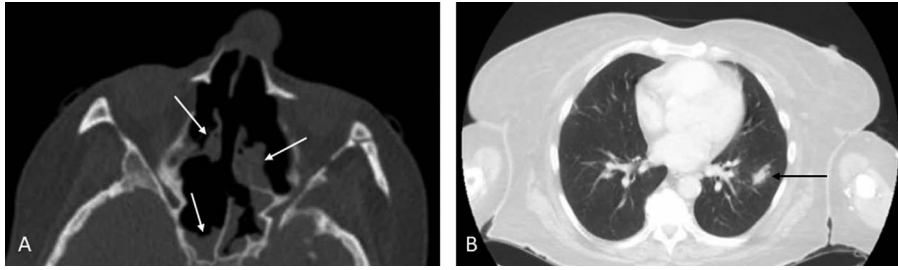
A, Computed tomography scan of head demonstrating extensive paranasal sinus mucosal thickening and amorphous soft tissue density (arrows). B, Computed tomography scan of chest showing a prominent nodule in the left lung (arrow).
